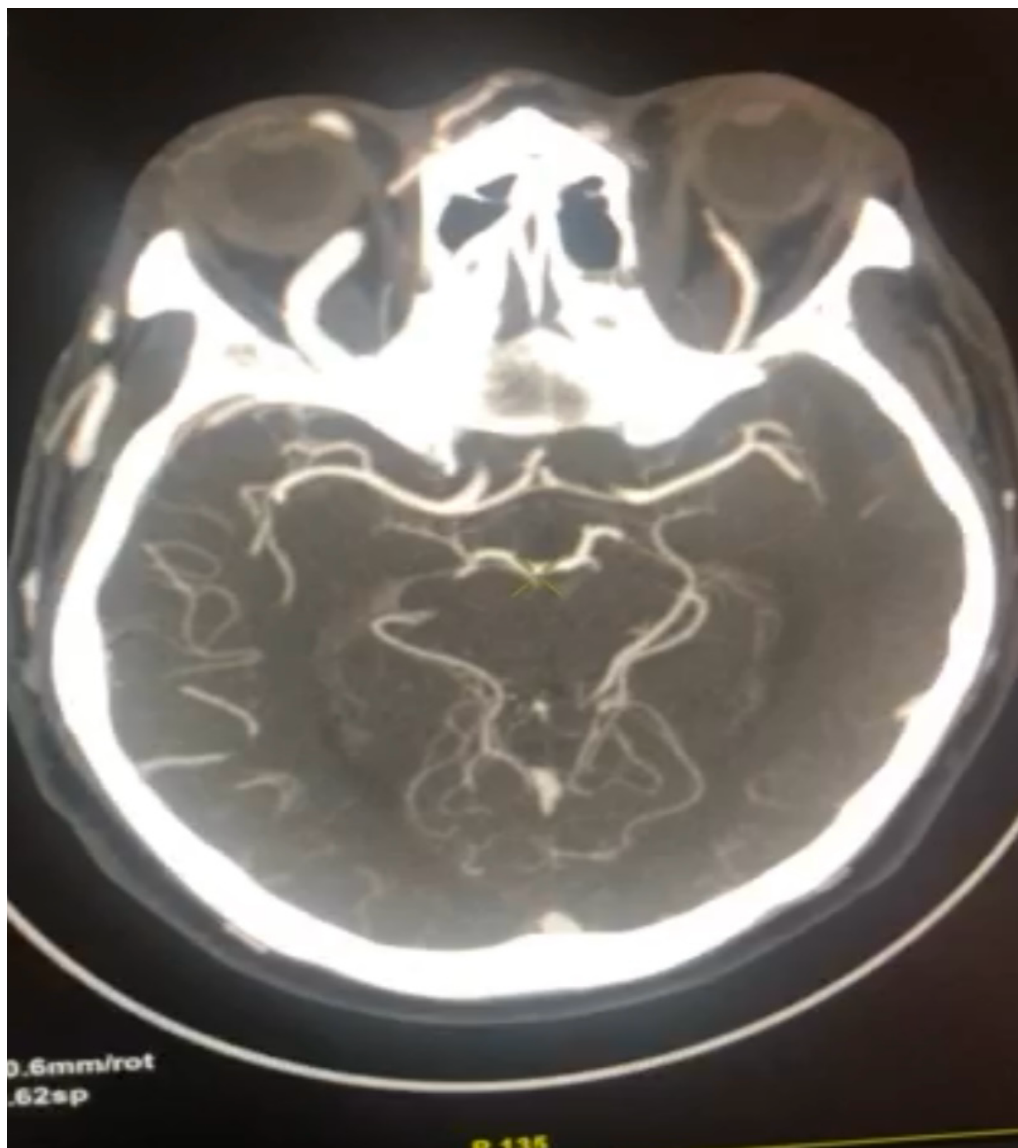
11.04.2024 CT – angiography of the head and neck vessels with intravenous contrast, sagittal section. Signs of carotid-cavernous fistula
